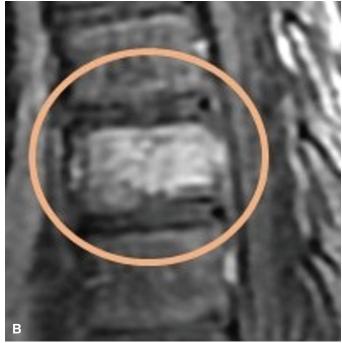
Vertebral Langerhans cell histiocytosis. A: Sagittal, CT scan, bone window, shows an osteolytic lesion of T9 vertebra (*circle*). B: Sagittal, T1W MR image with contrast shows homogeneous and intensely enhancing lesion of the vertebral body of T9 (*circle*) consistent with marrow infiltration. (Images courtesy of Vinay Kandula, MD, Nemours Alfred I. duPont Hospital for Children, Wilmington, Delaware.)
